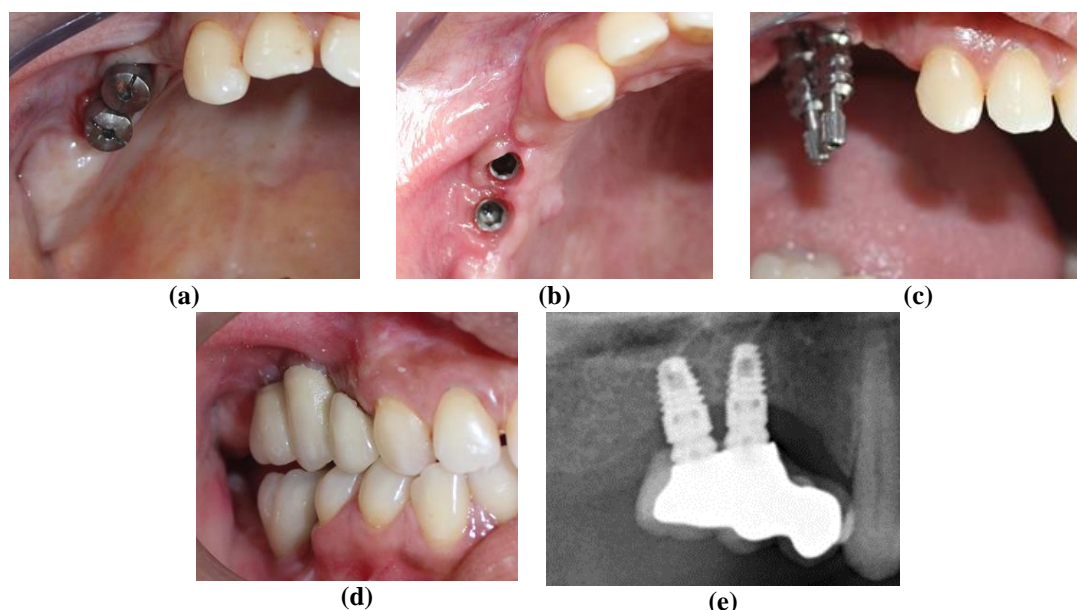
Stage 2 implant surgery; (a) Healing abutment placed, (b) Gingival cuff, (c) Impression coping, (d) Crown placement, (e) Post-operative radiograph
